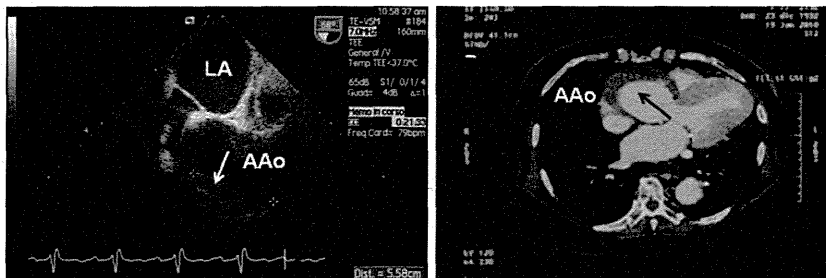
▲ Intramural hematoma. Transesophageal echocardiography (*left*) reveals ascending aortic aneurysm and aortic wall thickening (*arrow*) without accompanying dissection flap or false lumen. Contrast-enhanced computed tomography (*right*) demonstrates crescentic aortic wall thickening (*arrow*), a hallmark of intramural hematoma. (Courtesy of Rodolfo Citro, MD, Heart Department, University Hospital “San Giovanni di Dio e Ruggi d’Aragona”, Salerno, Italy). AAo ascending aorta, LA left atrium
